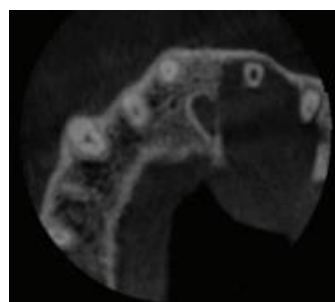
Preoperative Radiography. Periapical Radiolucent Lesion in the Left Maxillary Anterior Region
